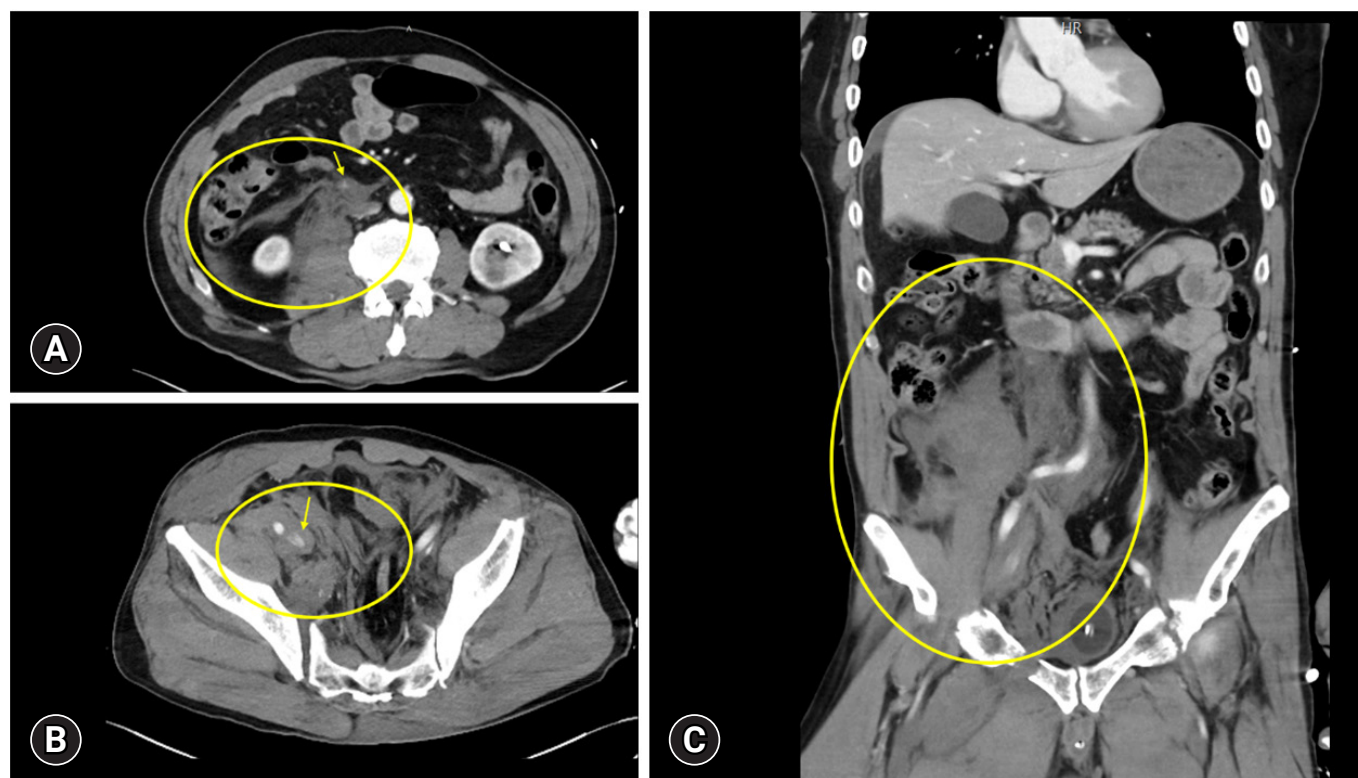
Initial abdominopelvic computed tomography findings. Retroperitoneal hematoma (circles) and extravasations (arrows) with a suspected inferior vena cava (IVC) and right external iliac vein (EIV) injury are shown. (A) Retroperitoneal hematoma and extravasations around infrarenal IVC. (B) Retroperitoneal hematoma and extravasations around right EIV. (C) Retroperitoneal hematoma and extravasations around infrarenal IVC and right EIV, a coronal view.
